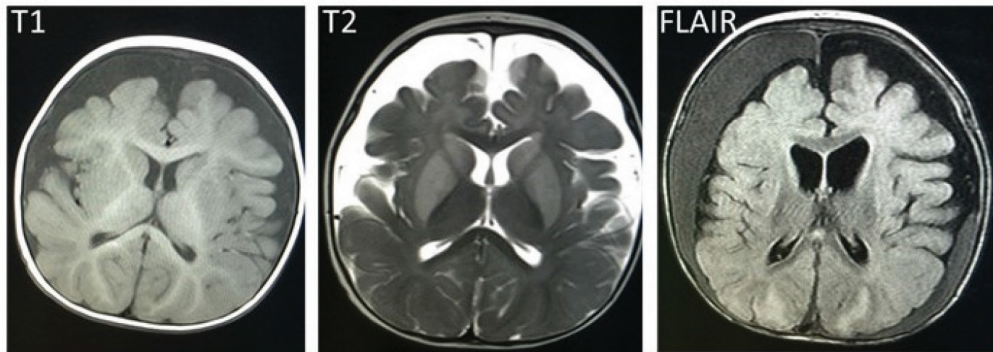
Brain MRI images in a patient with GA1 showing bilateral subdural collections and atrophy.
